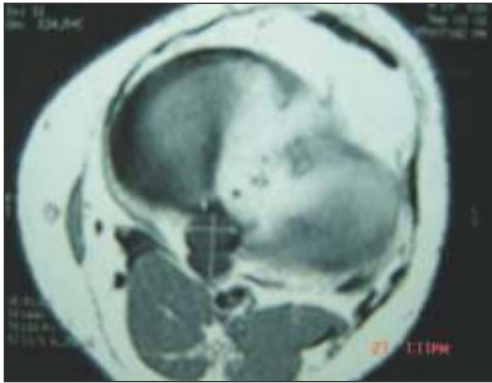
MRI showing soft tissue mass on T2 images overlying the anterior aspect of posterior cruciate ligament.
